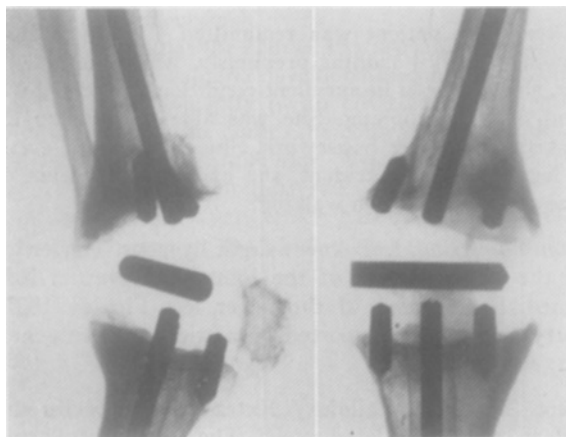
Case 2: roentgenograms 4 years 7 months after operation (4 months after accident).
